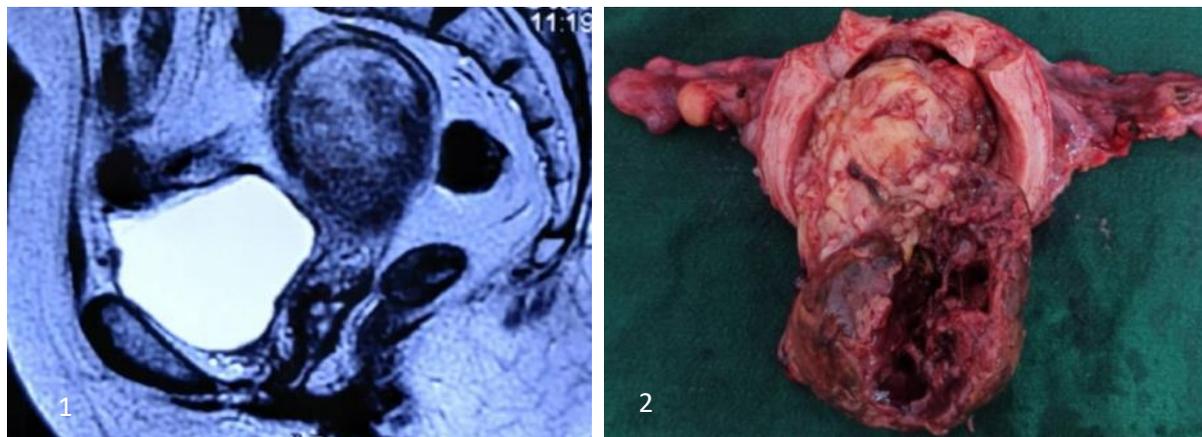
The MRI pelvis showing enlarged with distended endometrial cavity and widened endocervical canal
